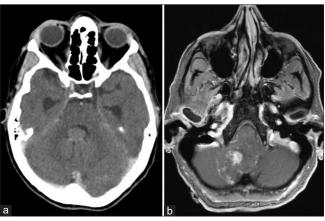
Axial CT and MRI. (a) A noncontrast CT representing hydrocephalus (note bilateral temporal horns) and a mass occupying the fourth ventricle. (b) An axial MRI with contrast demonstrating a paramedian hyperintense mass in the left cerebellar.
